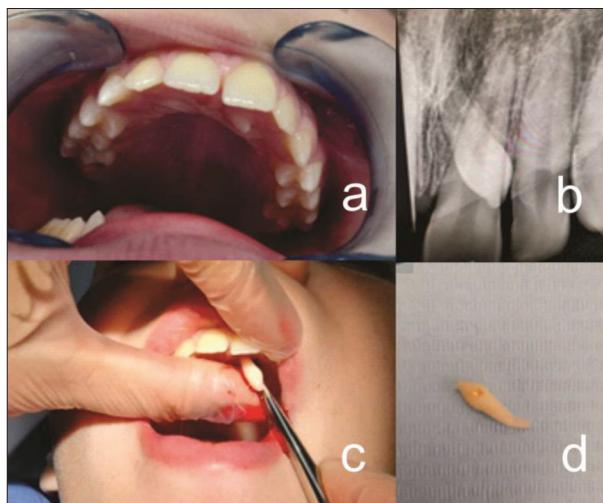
Erupted supernumerary tooth in the palate/mesiodens (a – clinical appearance, b – X-ray, c – tooth extraction, d – extracted mesiodens)
